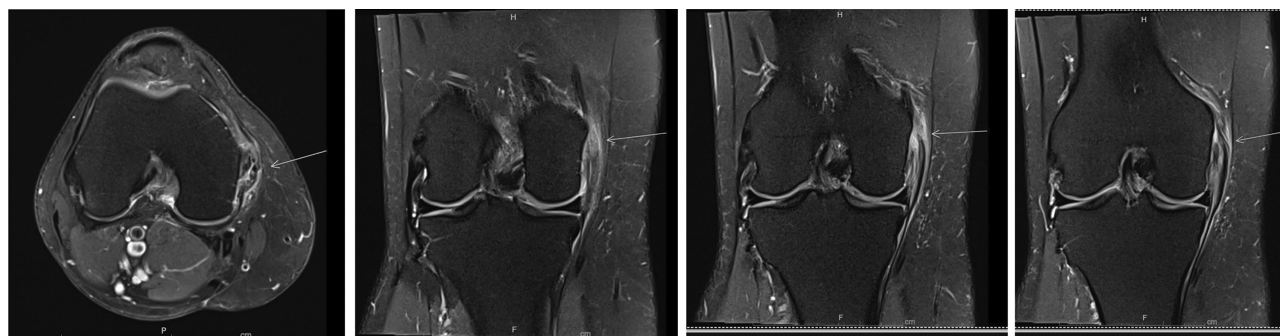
Magnetic resonance imaging. Images are labeled for series.
